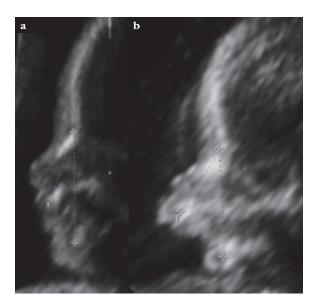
Ultrasound pictures of cases with BCL/P. Case 36 (A) with isolated incomplete BCL/P, the subjective normal profile has a MNM angle above the 95^{th} percentile (21.3°). Caser 47 (B) with trisomy 13 has a large MNM angle (33.7°).
